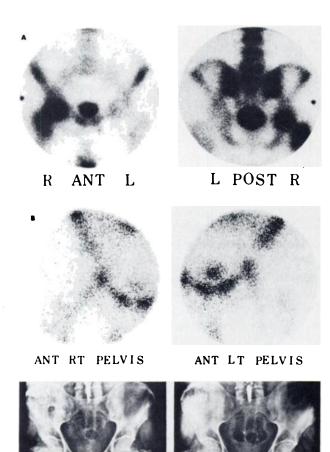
Case 2. (A) Bone scan with Tc-99m MDP. Abnormal uptake in right femoral head, neck, and trochanters. Rest of the bone scan was normal. (B) Bone-marrow scan 5 days later with Tc-99m sulfur colloid. Marrow activity is normal in both proximal femurs. (Aseptic necrosis usually causes diminished or absent marrow uptake.) (C) Radiograph on day of bone scan shows osteopenia with cortical thinning in right proximal femur. (D) Radiograph 3 mo later shows improvement, with no collapse or joint changes.
